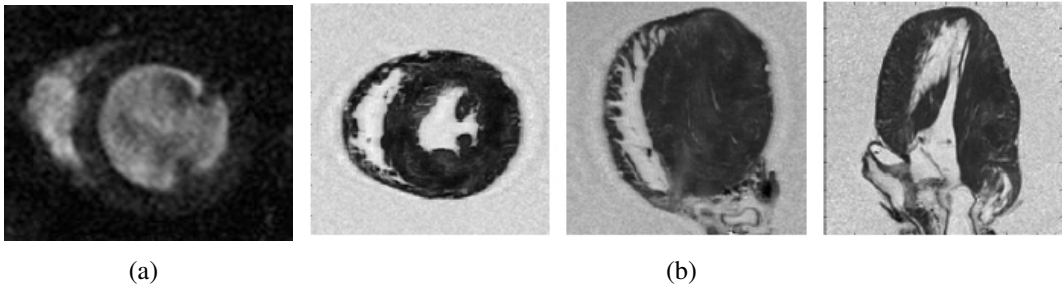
(a) Midventricular short-axis cine-MRI image at approximately end-diastole from *dataset*₁. (b) *ADC* image of one agarose-embedded heart DT-MRI dataset (*dataset*₁).
